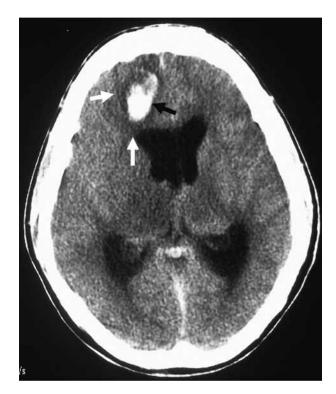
Axial contrast enhanced computed tomography image shows acute hyperdense parenchymal hematoma (black arrow) in right anteroinferior frontal region with hypodense peripheral edema (white arrows).
